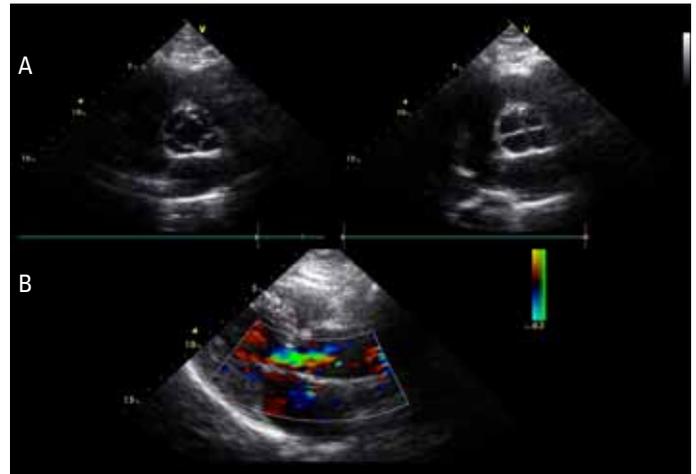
A) Quadricuspid morphology of aortic valve in transthoracic echocardiography, B) Aortic insufficiency in transthoracic echocardiography
